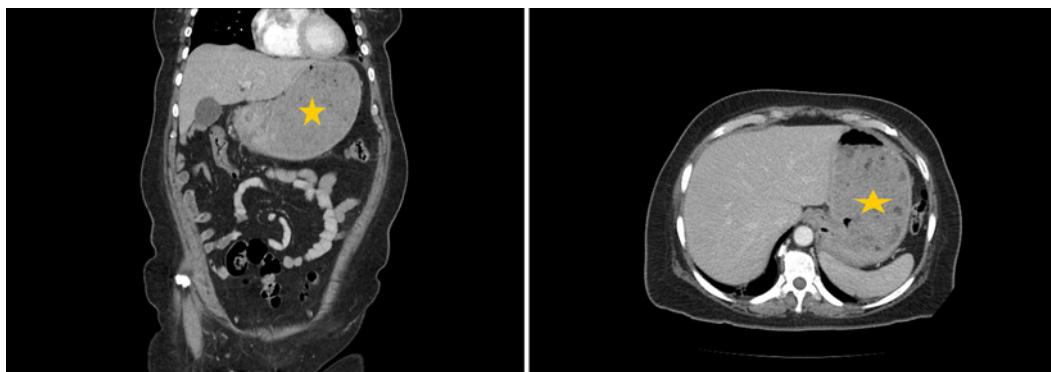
A contrast-enhanced CT scan of the abdomen and pelvis (coronal and axial planes) showing gastric distension with probable luminal narrowing involving the pylorus/proximal duodenum.
